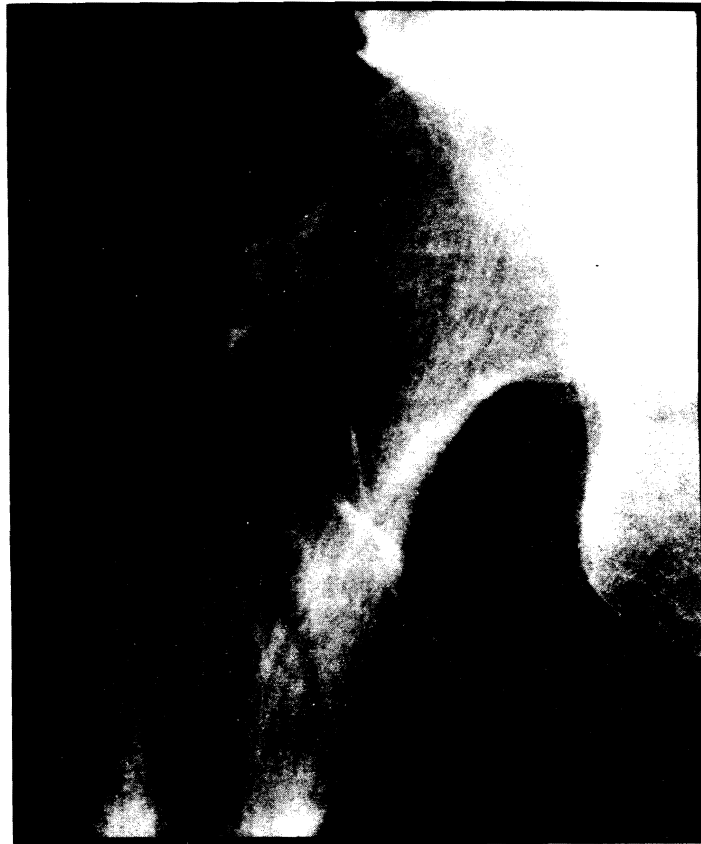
The roentgenographic appearance of the right upper hip in patient D, showing rarefaction and intertrochanteric fracture.
